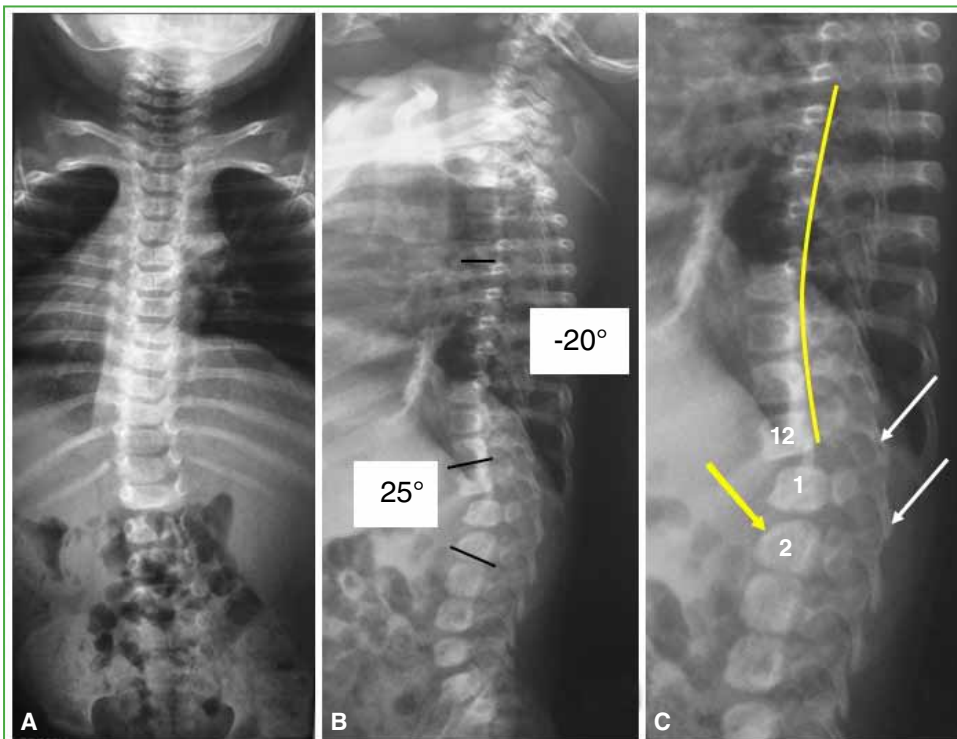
Initial radiographs. A. Anteroposterior. B and C. Lateral (standard and extended). Fracture of the body of L11 (yellow arrow), decreased facet contact (white arrows). T12-L1 subluxation. 25° hinge kyphosis, -20° thoracic lordosis.
